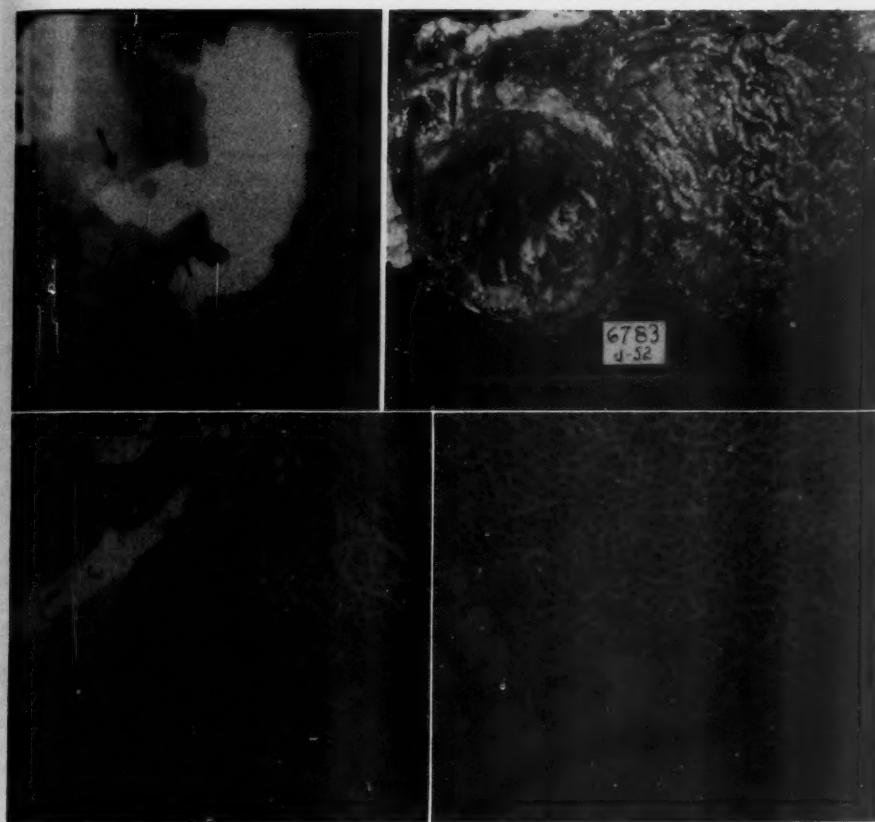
(Top left). G.I. x-ray revealed what was thought to be a duodenal ulcer, however irritability and narrowing of the prepyloric area suggested the possibility of a gastric lesion.
